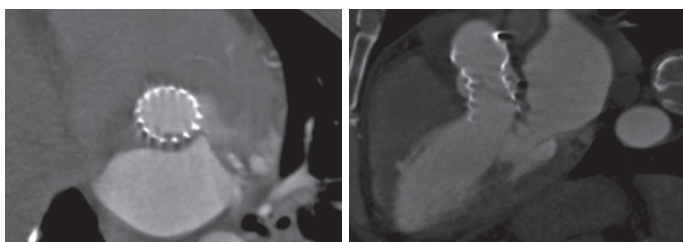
CT angiography.
